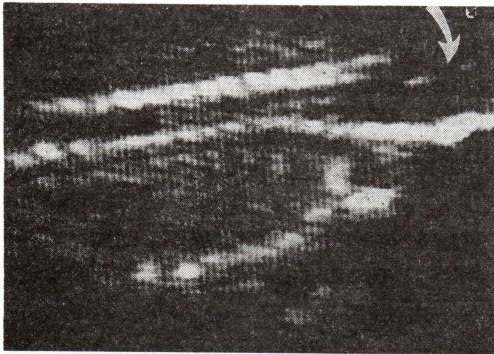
Transvaginal sonography shows longitudinal scan of fetal spine at 11.5 weeks from LMP demonstrating a cervical spina bifida.
